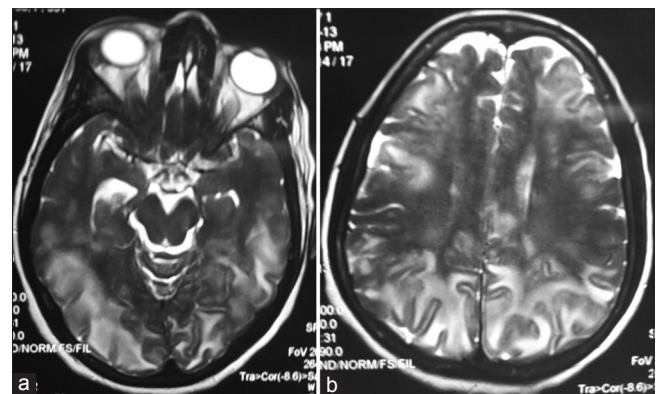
T2-weighted magnetic resonance imaging showing. (a) edema in posterior circulation region and; (b) diffuse white matter edema
